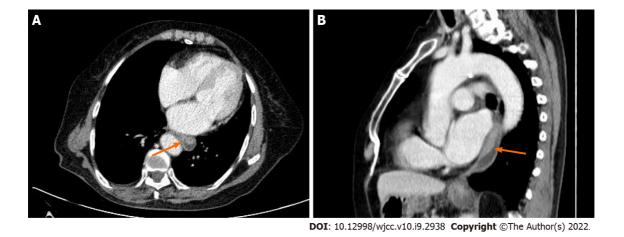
Chest computed tomography images of patient 4. A and B: A mass (orange arrow) protruding into the lumen with a complete mucosal layer. Enhanced computed tomography showed mild and homogeneous enhancement. No cystic change or necrosis was observed.
